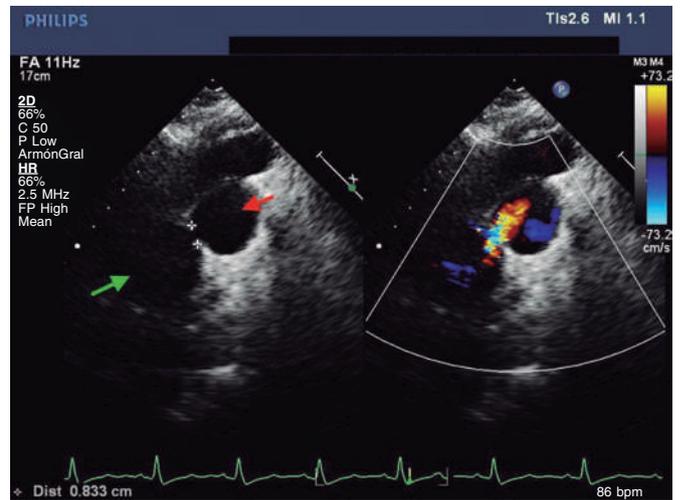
Echocardiographic right parasternal view showing the connection between the pulmonary trunk and pulmonary circulation with passage of flow. Green arrow: pulmonary trunk. Red arrow: right pulmonary branch.
